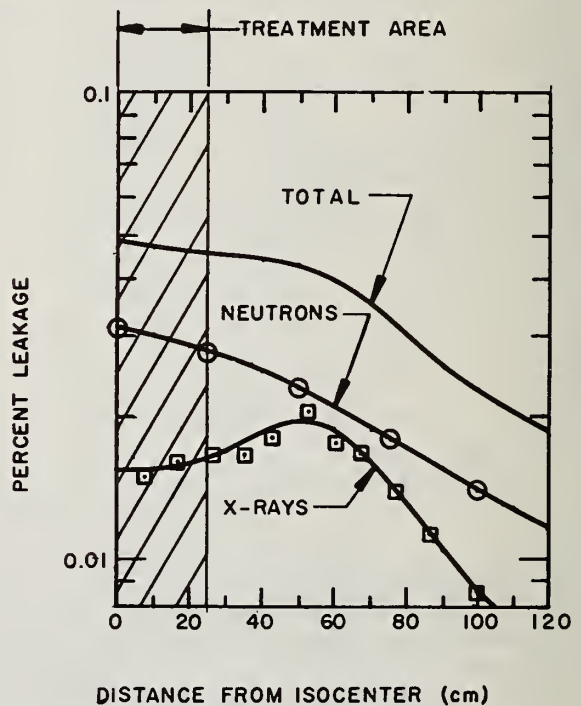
Neutron and x-ray leakage measurements in the patient plane of a Clinac 20: 15 MV x rays, 100cm SSD.
